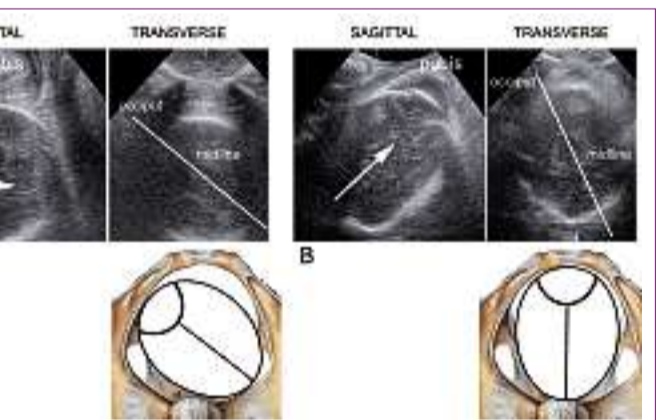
A comparison of sagittal and coronal planes obtained by 3D ultrasound to evaluate the engagement and descent of the fetal head. In A, the sagittal plane indicates that the direction of the fetal head is parallel to the symphysis (white arrow), while the transverse plane demonstrates that the midline echo of the brain is directed with an angle that slightly exceeds 45° with regard to the antero-posterior axis of the pelvis. These two observations suggest that the fetus is in the midportion of the pelvis and that the largest part of the head has not yet reached the ischiatic spine. Extraction with vacuum or forceps would present a high risk of failure and trauma in such a case. In B, the sagittal plane demonstrates that the direction of the head forms an acute angle with the symphysis, while the transverse plane indicates that the midline is almost vertical. This suggests that the largest circumference of the fetal head has passed the ischiatic spine and that fetal extraction, if necessary, can be safely performed with virtually no added risk over a spontaneous delivery. The position of the occiput is not obvious from these images and was identified by the standard suprapubic scanning and identification of the fetal spine.
